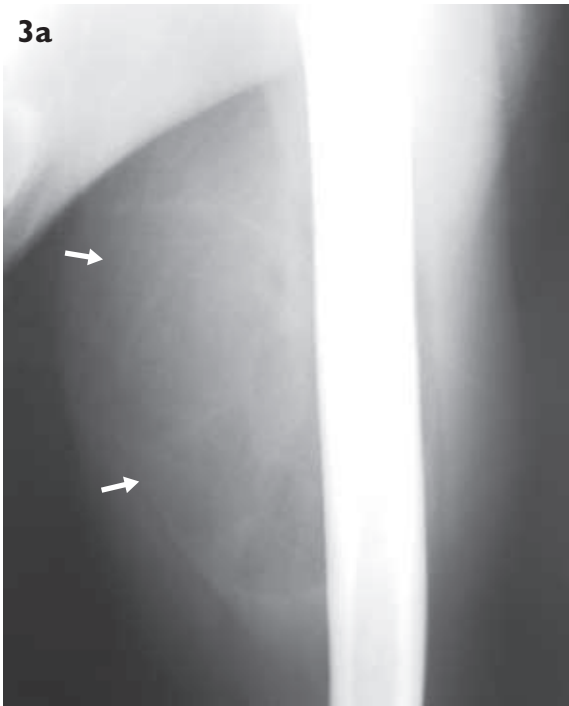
Imaging appearances of an intramuscular lipoma in a 65-year-old woman. (a) Anteroposterior radiograph of the left humerus shows an oval area of low-density (arrows) in the soft tissues. (b) Coronal SE T1-W MR image shows a well-defined hyperintense mass (arrows) within the biceps muscle. (c) Axial SE T1-W MR image shows the mass to be mainly situated within the biceps muscle. It also extends posteriorly to involve the triceps muscle and into the axillary fossa. (d) Enhanced axial fat-suppressed SE T1-W and (E) axial fat-suppressed fast SE T2-W MR images show the lesion has a homogeneous hypointense signal. The relation of the lipoma to the adjacent vascular structures are well demonstrated. Note that the signal intensity of the mass is identical to that of the subcutaneous fat on all MR sequences.
